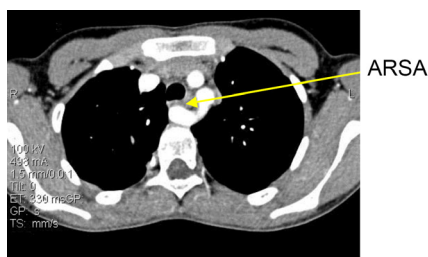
Cross sectional view of aberrant right subclavian artery in computed tomography (CT) scan.
